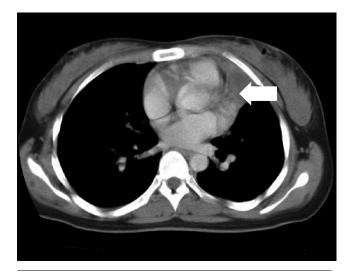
Computed tomography of chest shows a welldefined cystic mass(white arrow), which is about 2.8 x 3.8 x 5 cm in dimension in the left upper pericardial region of the anterior mediastinum with increased density of the thymus.
